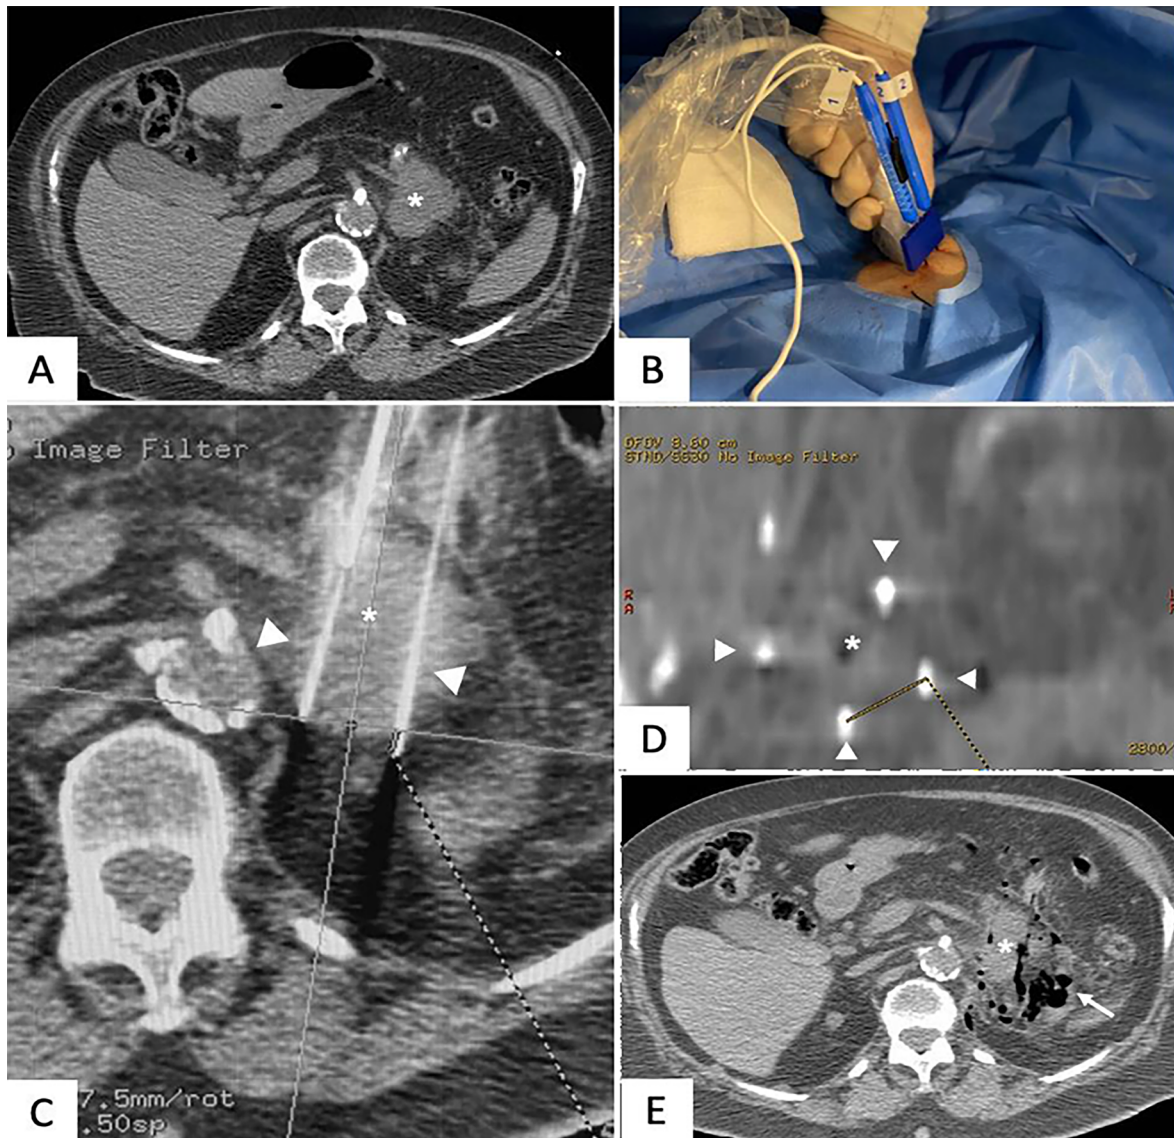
Percutaneous IRE of a local pancreatic recurrence. A. Pre-treatment CT showing local recurrence (asterisk); B. Percutaneous positioning of the probes; C. Probe (arrowhead) positioning confirmation within the tumor (asterisk); D. Inter-electrodes measurements (dashed line) between the probes (arrowhead); E. Immediate CT after IRE shows the lesion (asterisk) with similar aspect surrounded by gas (arrow).
